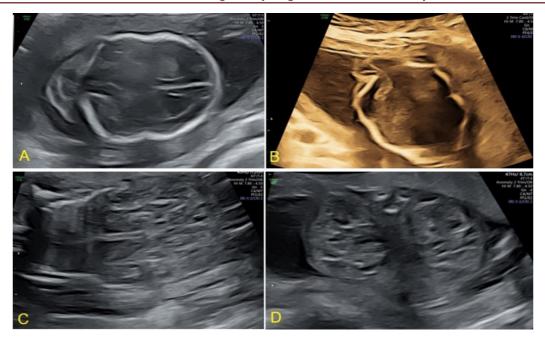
Ultrasound images of fetus showing occipital encephalocele with bilateral multicystic hyperechogenic kidneys A and B showing occipital encephalocele (axial)
